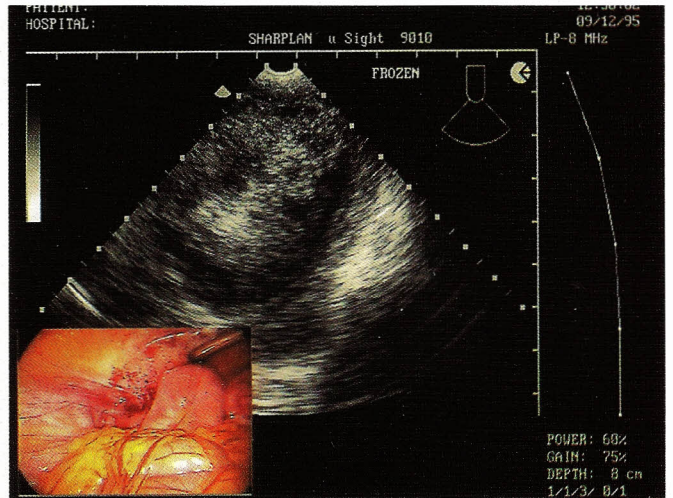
Intraoperative ultrasound shows heterogeneity more clearly.
